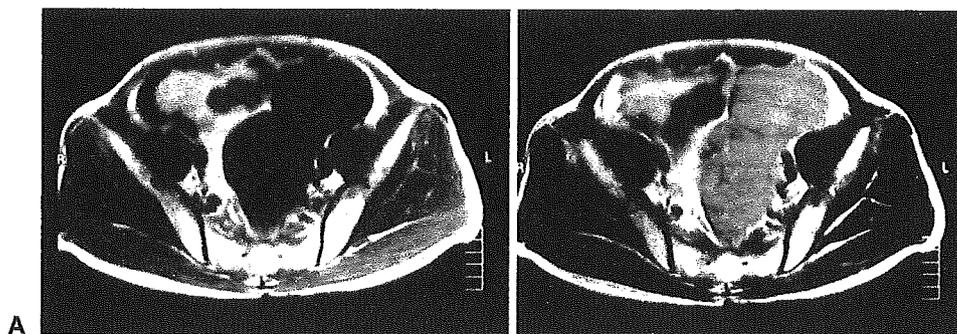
T1-weighted magnetic resonance imaging (MRI) showed a mass lesion of low signal intensity in the pelvic cavity (A). The mass showed a high signal intensity on T2-weighted MRI (B)
